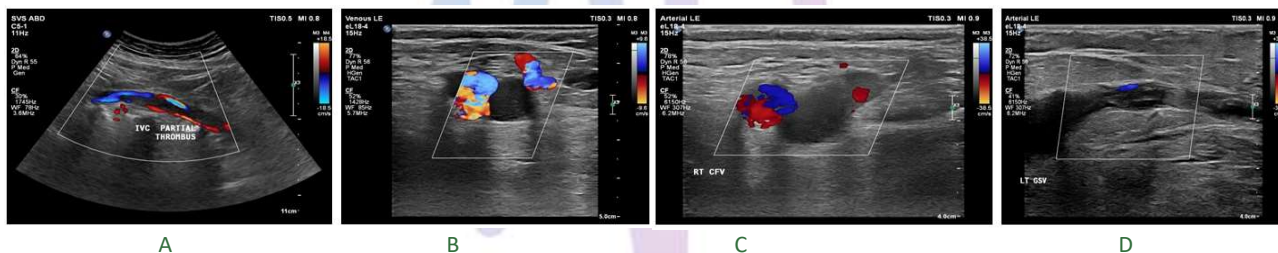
Doppler ultrasonography of both lower limbs a) presence of partial thrombus in infrarenal inferior venacava. b) presence of complete thrombus in right common femoral vein. c) presence of complete thrombus in left common femoral vein. d) presence of partial thrombus in left proximal great saphenous vein.
